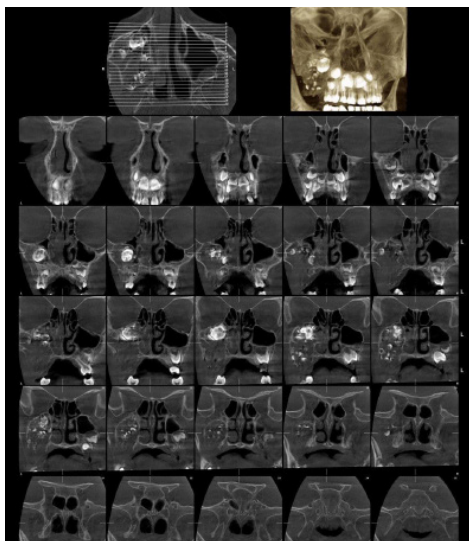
The panoramic radiograph shows multiple tooth-like structures in the right posterior maxilla. Superiorly displaced tooth #3 to the floor of the right orbit is observable. Teeth #2 is not detectable on this radiograph. Cone-beam computed tomography (CBCT) was suggested for more investigation of any impingement of the maxillary sinus. The lesion was extended to the lateral wall of the nasal cavity, medially, and the floor of orbit, superiorly. A CBCT examination showed that teeth #2 and #3 (universal numbering system) were displaced superiorly to the inferior rim of the orbit. Expansion and thinning of the posterior border of the maxillary sinus were evident in axial views (Figure 4).
